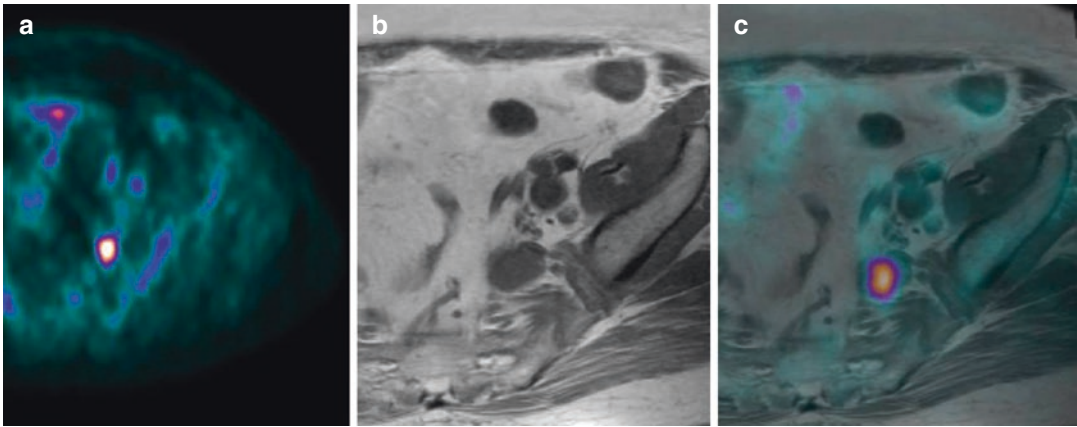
Axial PET (a), T1-weighted MRI (b), and PET/MRI (c) views showing focal, pathologic ^{18}F -FMC uptake in a left iliac lymph node, 2 cm wide
